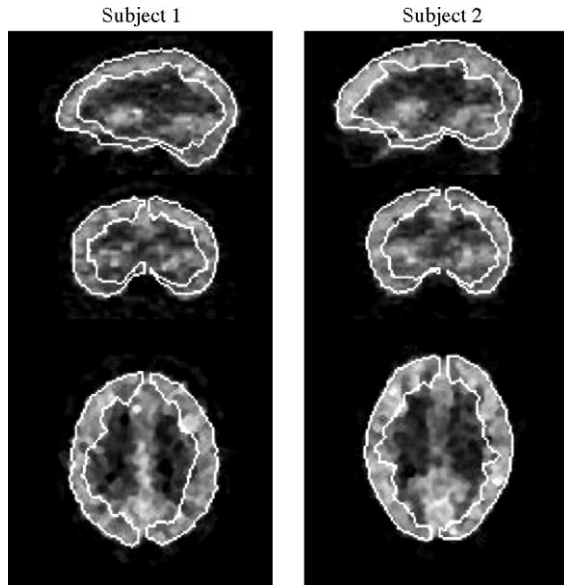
The extracted VOIs overlayed on the original FDG-PET images.
